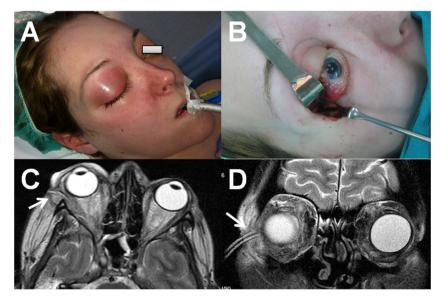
(A) External view of patient. (B) Al right intraorbital abscess drained by canthotomy and cantholysis. An axial (C) and coronal (D) high resolution T2-weighted MRI scans show the drainage of the abscess (*arrows*). There is no disease in the maxillary and ethmoid sinuses.
